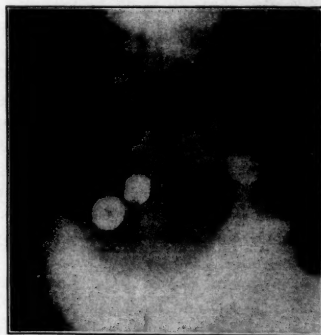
shows x-ray taken on twenty-fifth day. Murphy buttons dispersed.
